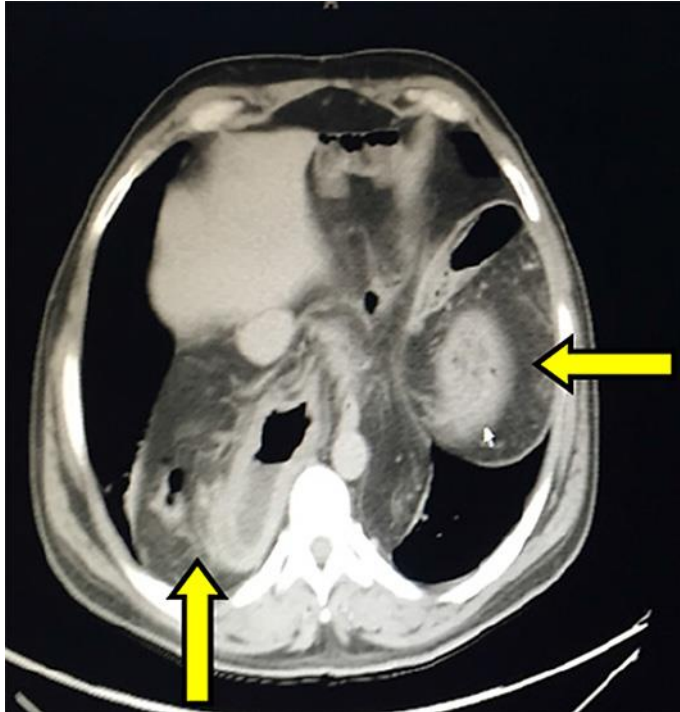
CT scan reveals right herniation of abdominal viscera (antrum, pylorus, duodenum into the posterior right thoracic cavity) consistent with right BH.
